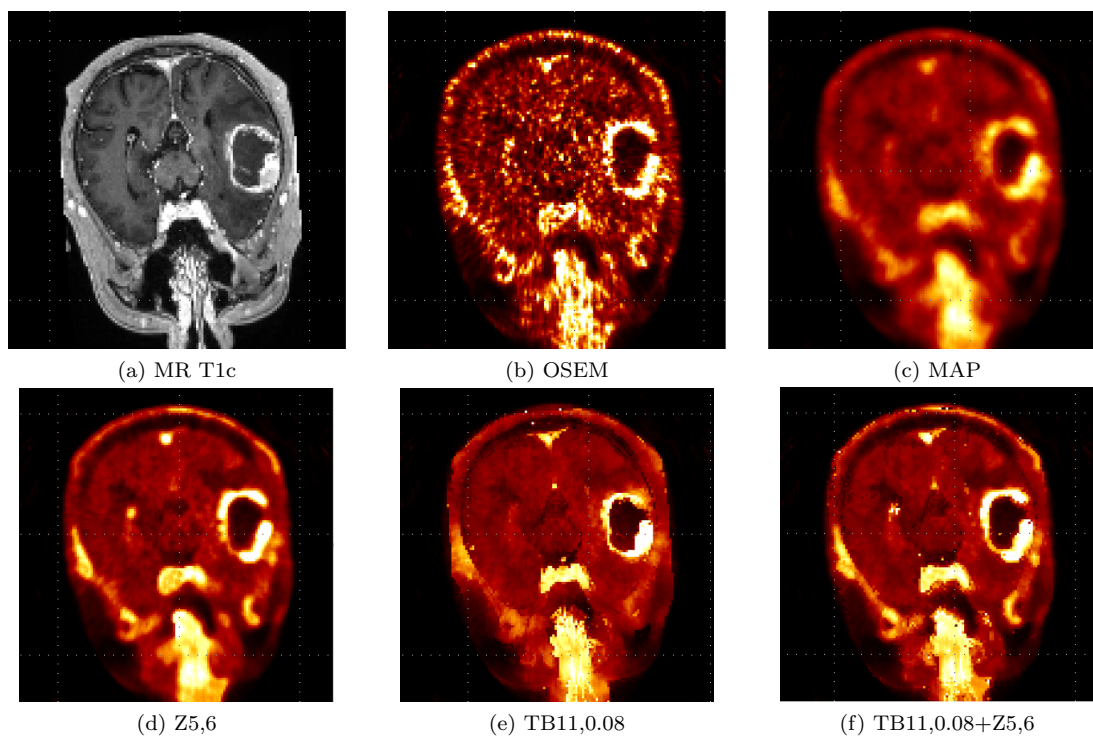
Clinical data from the mMR scanner, T1c MR image (a) and reconstructed images (b)–(f).
